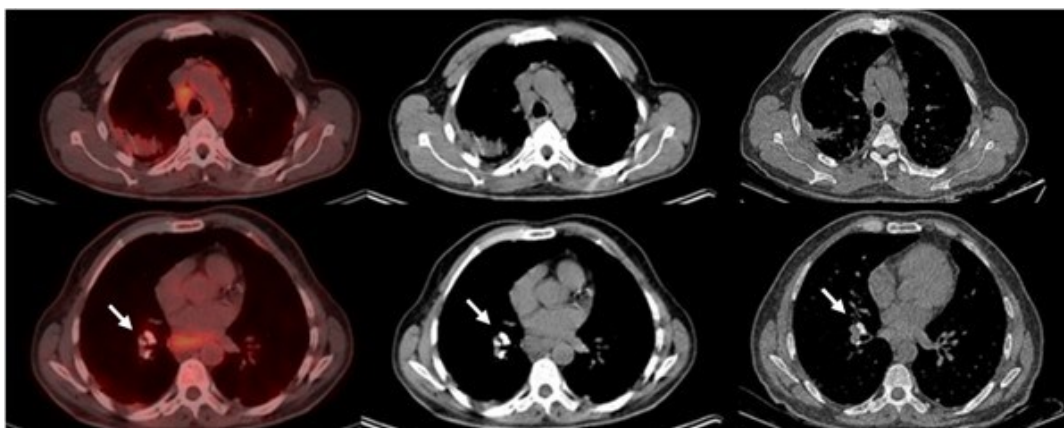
[^{18}F]FDG PET/CT and HRCT evaluation of mediastinal lymphadenopathy. From left to right: axial fused [^{18}F]FDG PET/CT, low-dose CT, and corresponding HRCT images. The PET/CT fusion images reveal moderate metabolic activity within the mediastinal lymph nodes, which also demonstrate characteristic “eggshell” calcifications identifiable on both PET/CT and HRCT scans (arrows)
